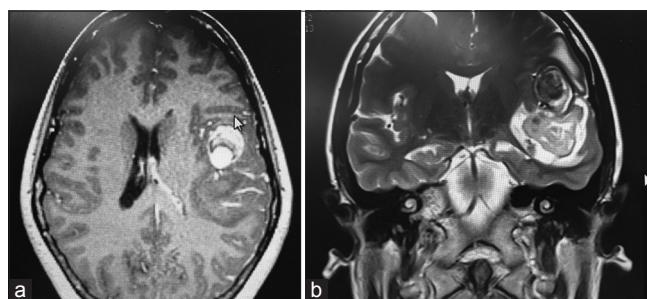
(a) Contrast enhanced axial magnetic resonance imaging: Partially thrombosed pseudoaneurysm. (b) Coronal T2 magnetic resonance imaging of lesion
